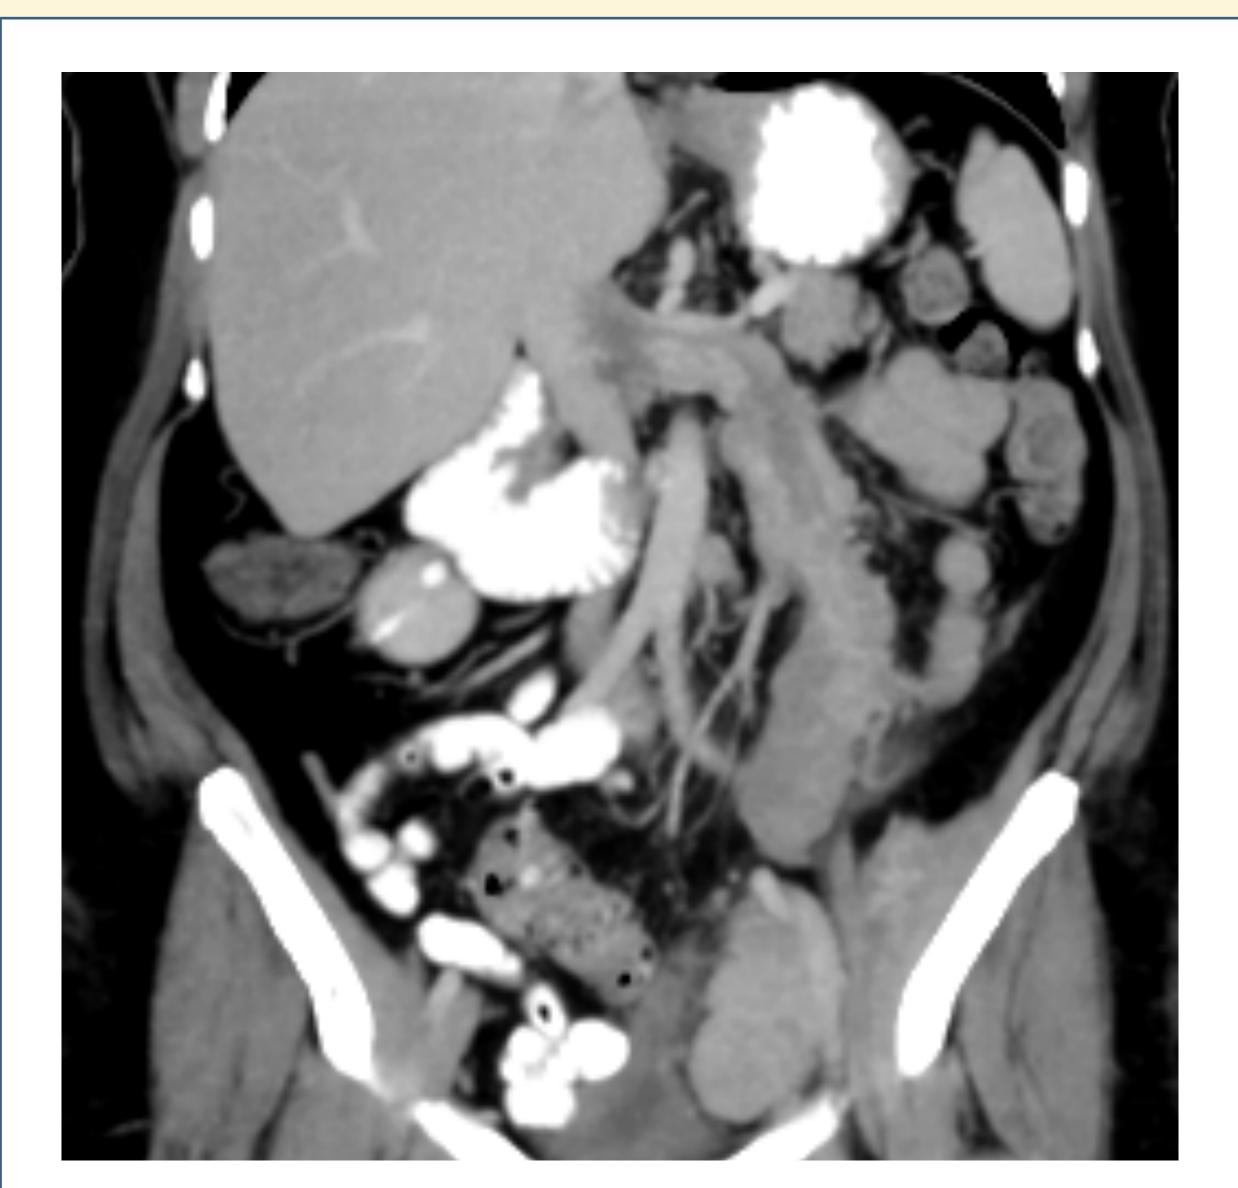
Coronal CT approximately 3 years after diagnosis shows continued marked expansion of the left gonadal vein with relatively hypodense intravascular tumor probably mixed with bland thrombus extending into the inferior vena cava; additional intravascular tumor involving the left iliac veins and branches in the left pelvis.
